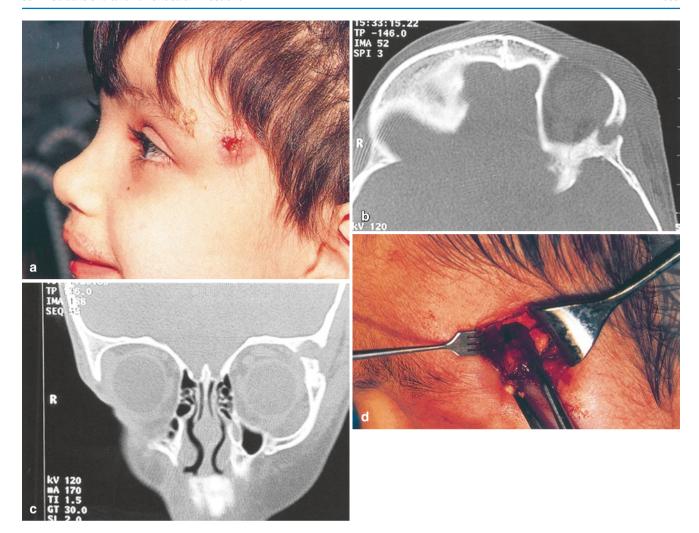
Dermoid misdiagnosed as recurrent orbital cellulitis. (a) This 8-year-old had a recurrent episode of orbital cellulitis and purulent draining through a temporal skin fistula following removal of a "sebaceous cyst." (b) The axial CT shows soft tissue edema and a natural
